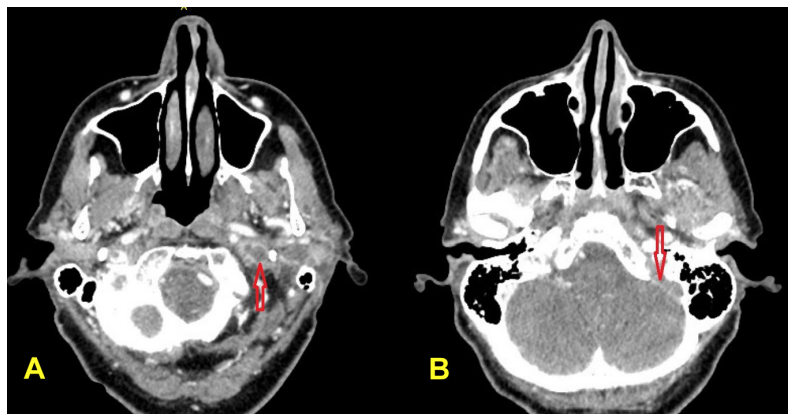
Initial CT scan of the head enhanced with contrast medium. Thrombosis of the jugular left vein (A) and filling defect of the left sigmoid sinus (B).
